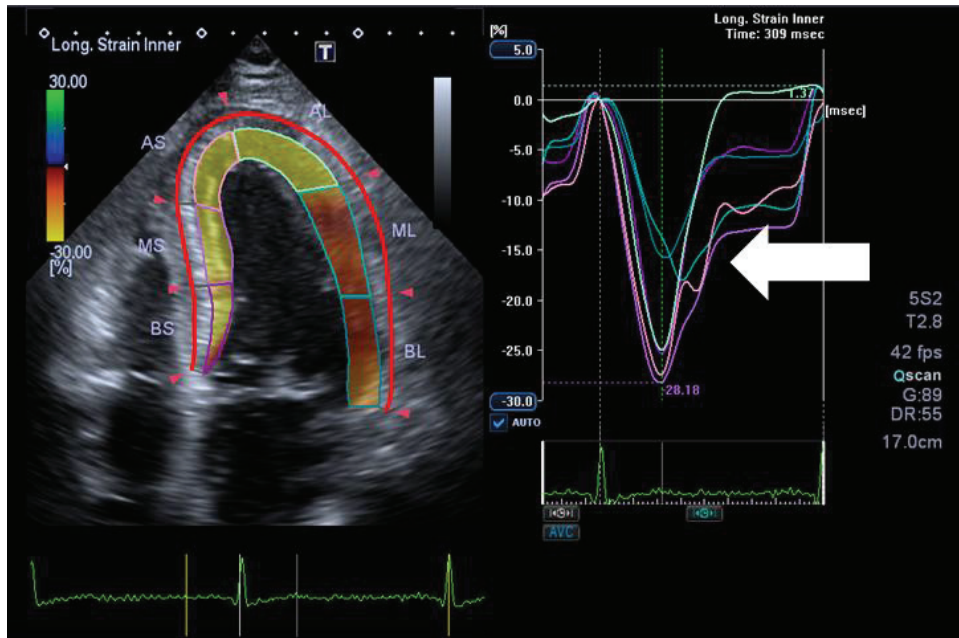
Six endocardial longitudinal strain segments in apical 4-chamber view in a patient with non-ST elevation (NSTE) acute coronary syndrome (ACS) with occluded Left Circumflex (LCX) artery. Automatic strain analysis shows reduced color coded endocardial strain values in the segments supplied by the LCX artery on the left. Color-coding from yellow to green indicates strain from +30% to -30%. Yellow indicates preserved strain. Brown indicates areas with reduced strain. Epicardial shortening was assessed along the red line. Strain curves for the 6 endocardial segments are displayed on the right. The curves representing the segments supplied by the LCX artery show reduced peak systolic longitudinal strain values of -15% (white arrow).³⁵
